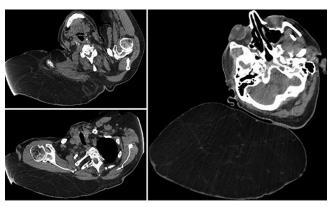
Preoperative chest computed tomography scan
